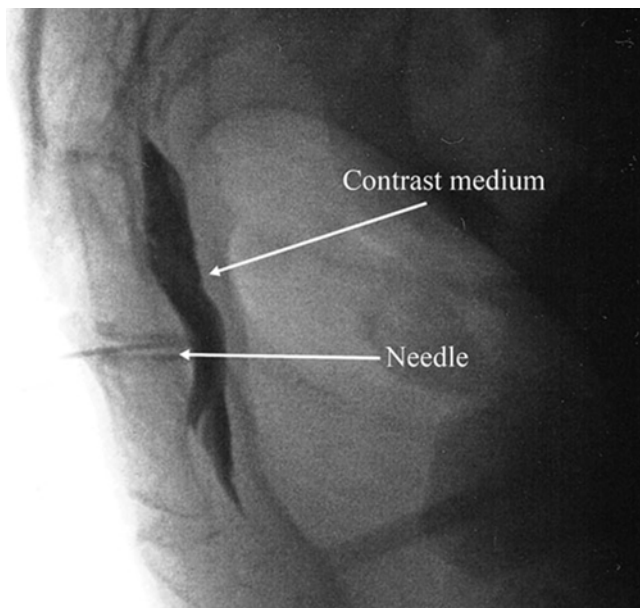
Lateral radiographic view of contrast medium anterior to sacrum
